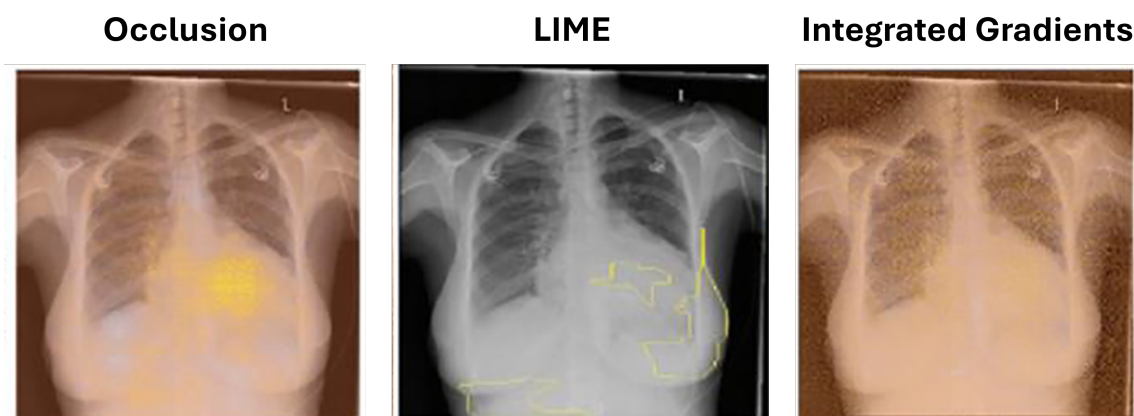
Example uses of perturbation-based attribution methods for model interpretability which shows the comparison of several approaches to interpretation for identifying congestive heart failure on chest x-rays (Seah et al., 2018) [43]
